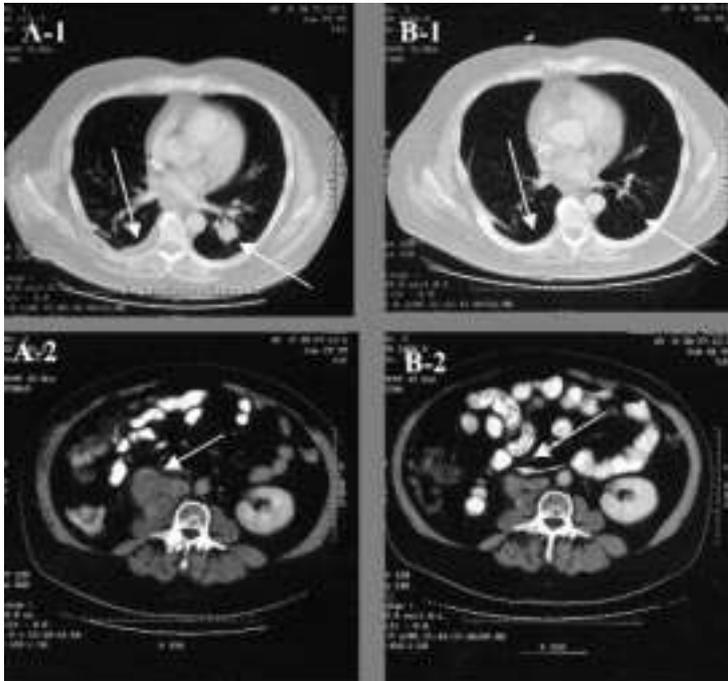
Regression of metastatic RCC in multiple metastatic sites. Day 100 post-transplant CT images (A1, A2) of a patient with RCC with diffuse metastatic disease involving the lungs, pleura, and retroperitoneum. Four weeks later (B1+B2), following the withdrawal of CSA, repeat CT scans revealed complete resolution of all pulmonary metastatic disease (B1) and partial regression of metastasis in the retroperitoneum (B2).
